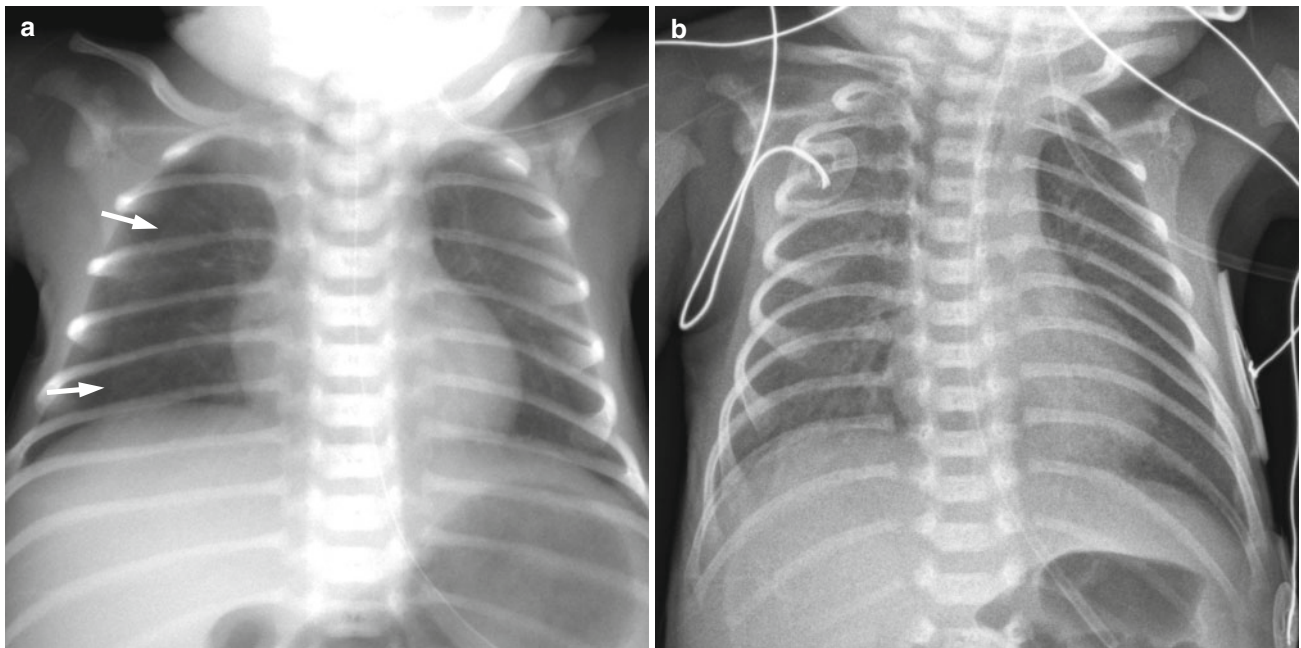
Artifacts mimicking pneumothorax on neonatal chest radiographs. (a) Skin fold. Prominent skin fold (*arrows*) can be mistaken for pneumothorax. (b) Rotated position. Anteroposterior chest
